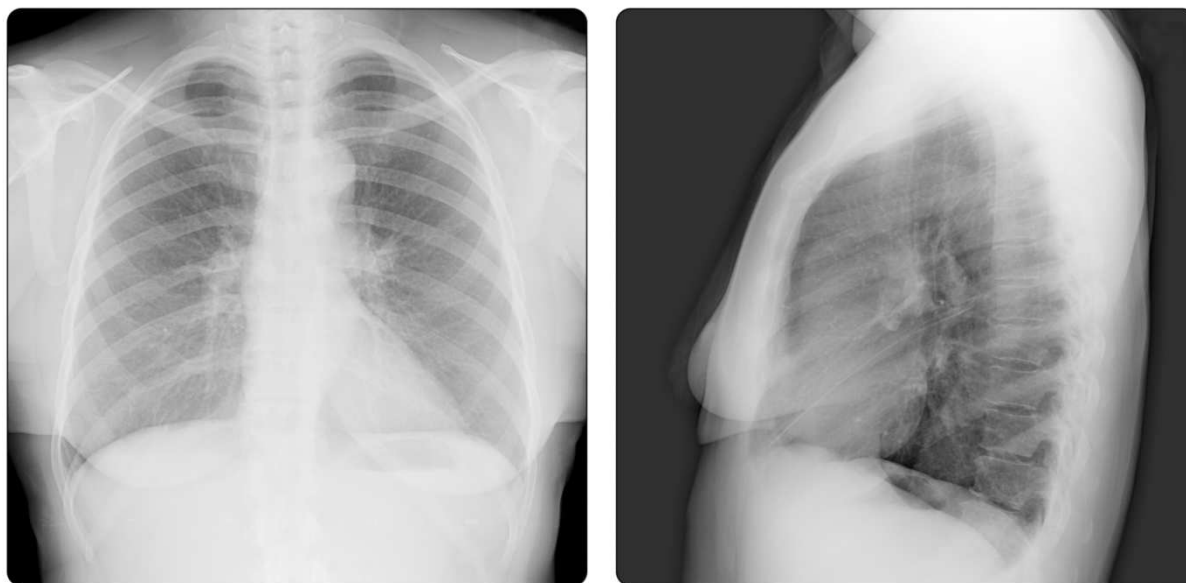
Initial PA and lateral X-ray images.
